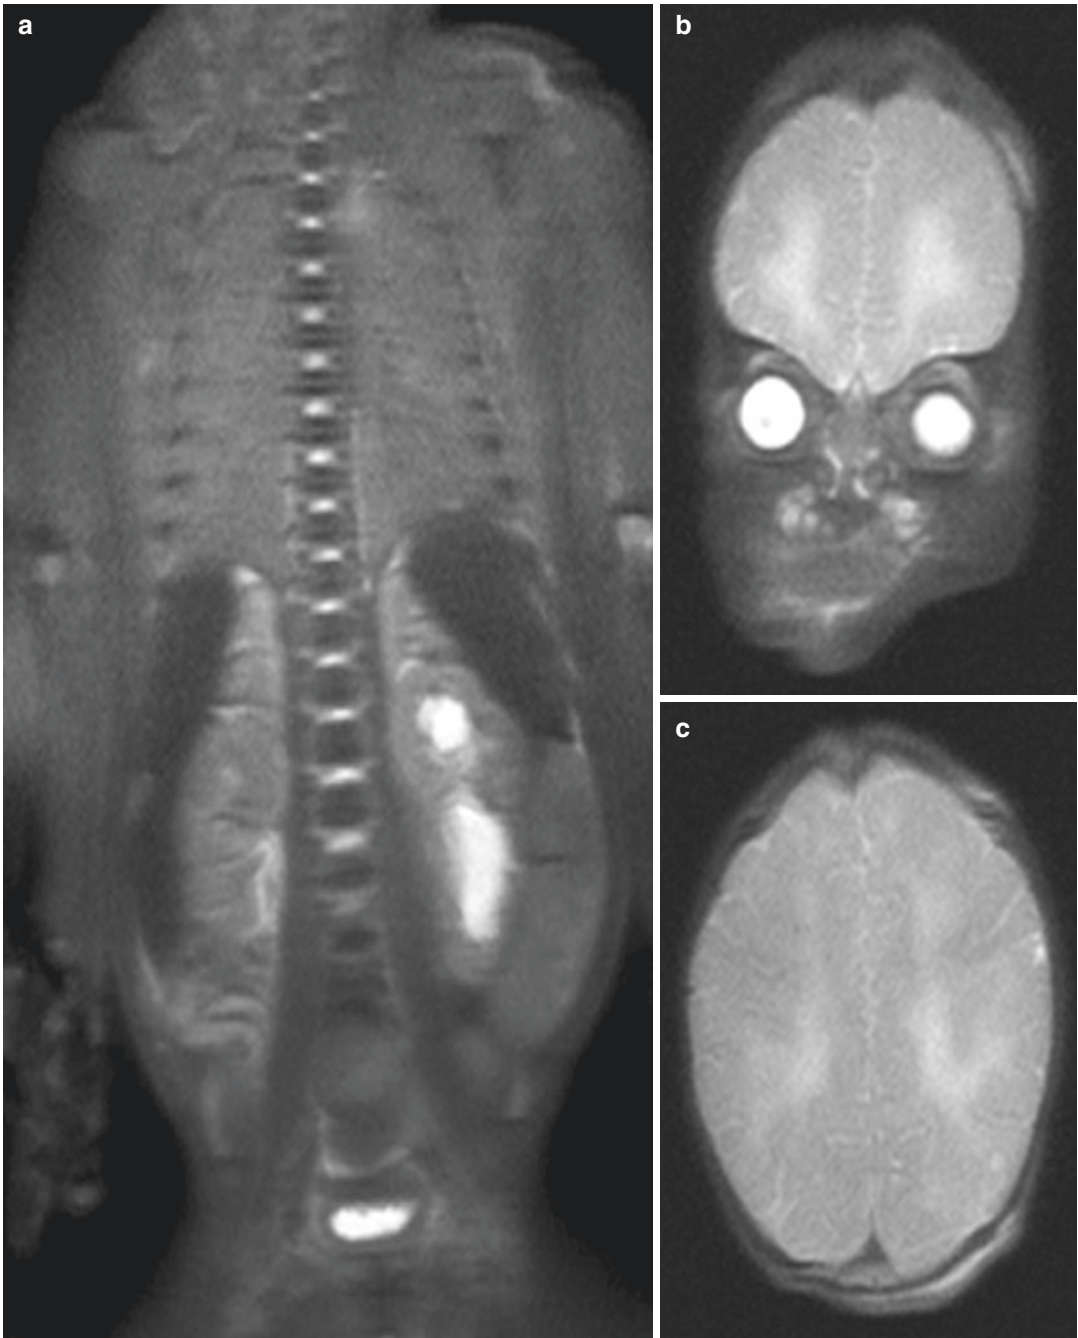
Fetal MRI T2-weighted images show hydronephrosis (a) and encephalopathy of hypoxic-ischemic genesis on coronal (b) and axial (c) view
